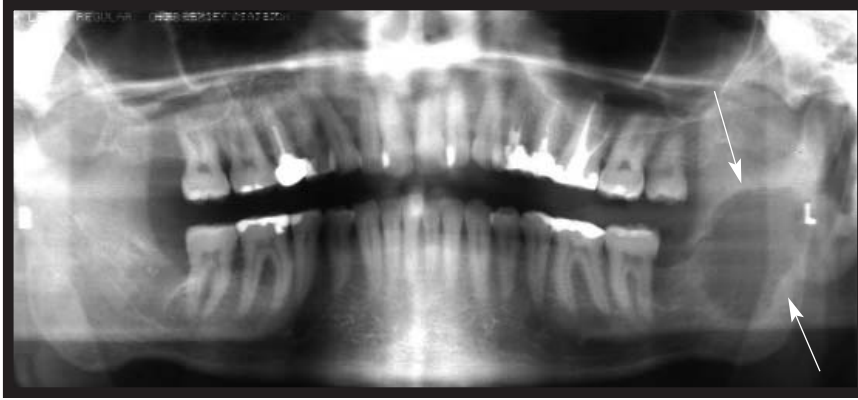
Panoramic radiography of the left lower jaw revealed a well-defined, 2×3-cm radiolucency.
